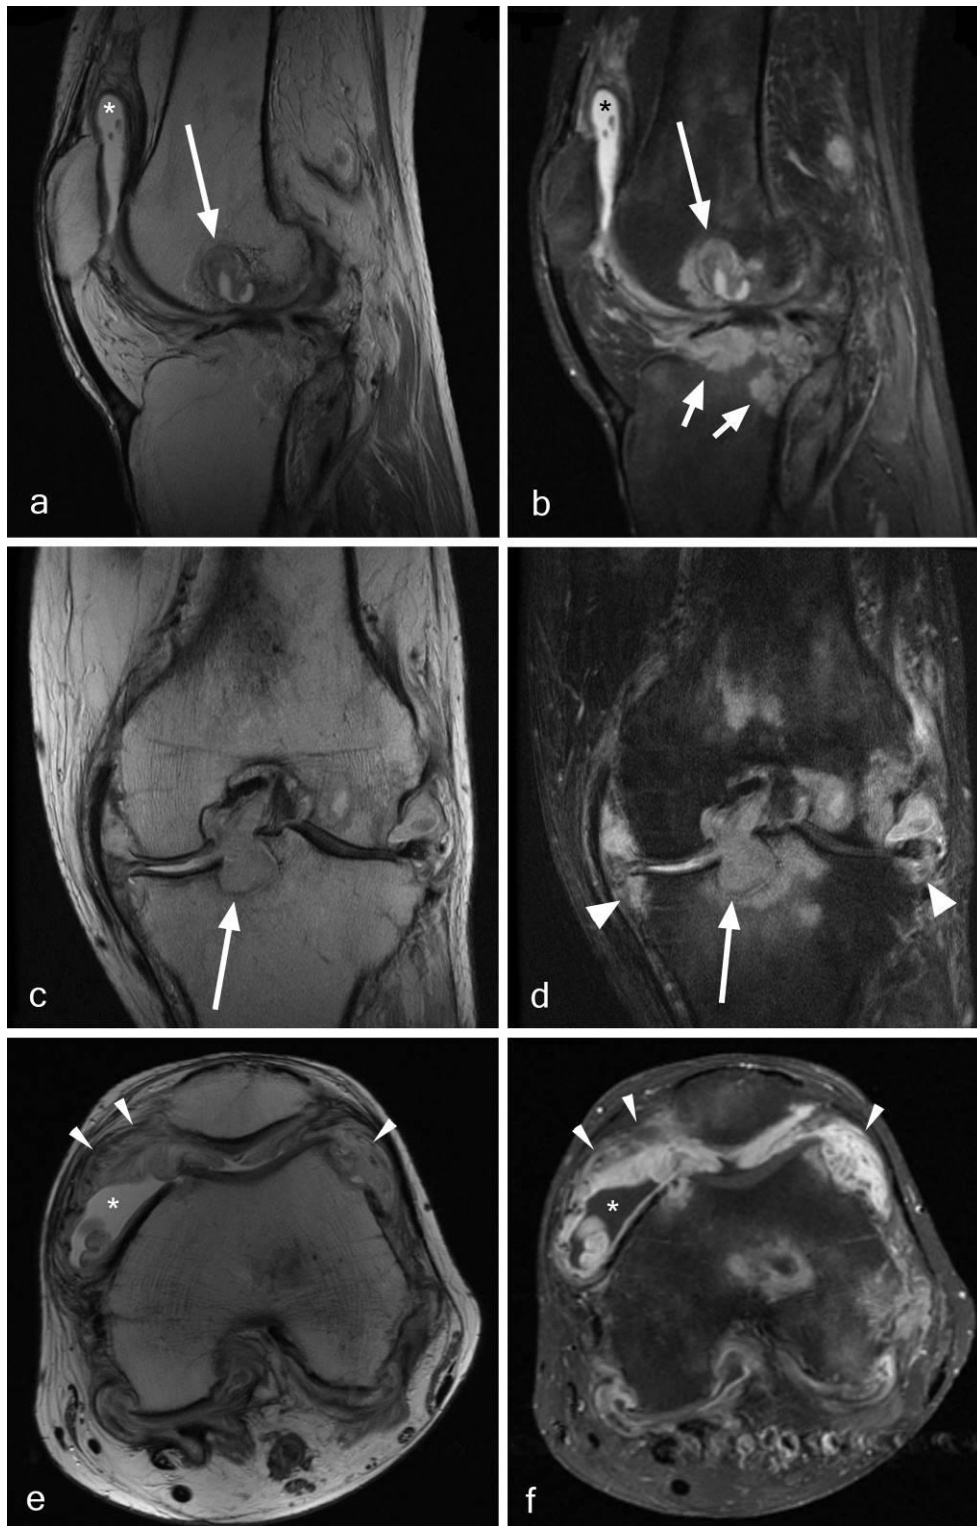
48-year-old woman with *Mycobacterium kansasii* synovitis and osteomyelitis of the knee. MR examination of the left knee was performed seven years after the initial MRI (Figure 2). Intravenous gadolinium contrast was administered prior to figure 4f.
